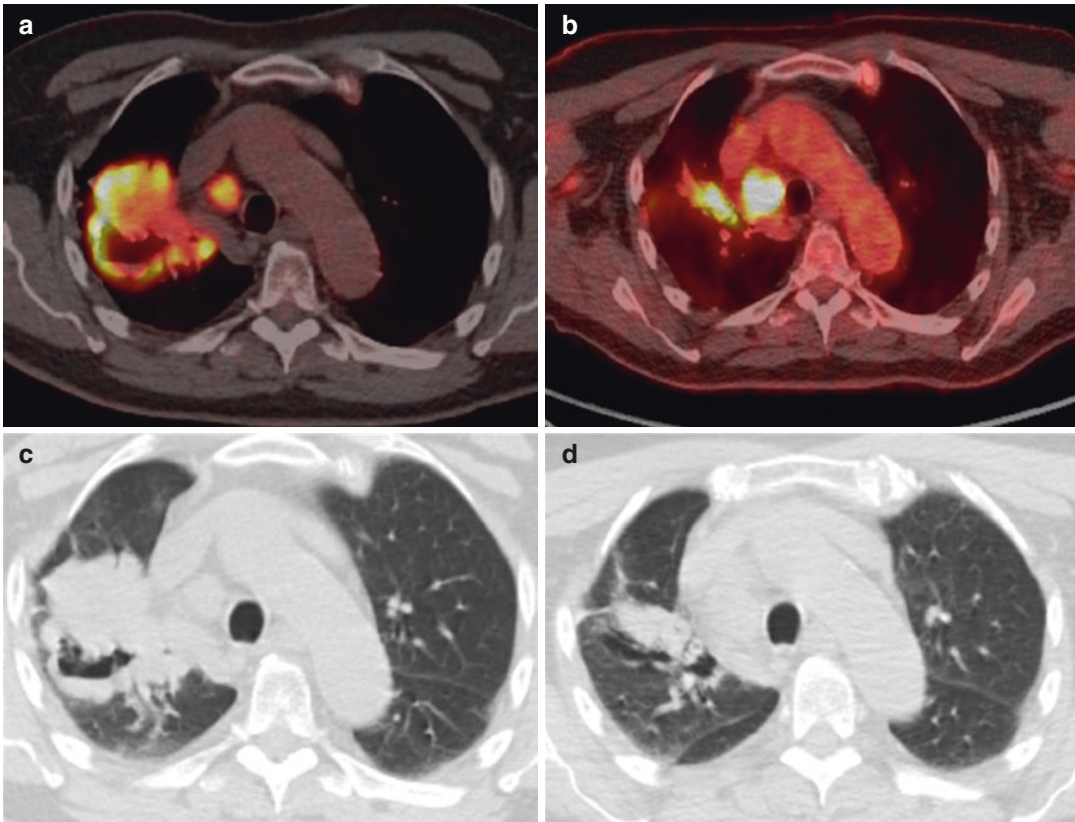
81-year-old man with history of metastatic urothelial carcinoma of a solitary left kidney, treated with pembrolizumab. Pretreatment fused FDG PET-CT (a) and non-contrast CT of the lungs (c) show a large, FDG-avid right upper lobe mass and right paratracheal adenopathy. After 8 weeks of treatment, follow-up fused FDG PET-CT (b) and non-contrast CT of the lungs (d) show interval
